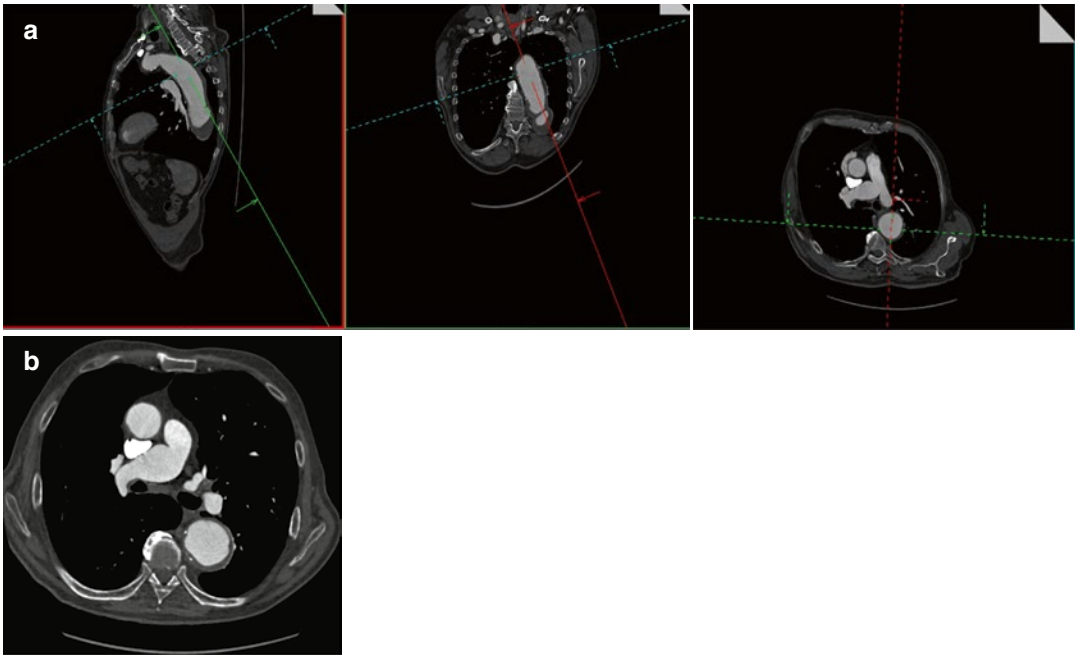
A 77-year-old woman with descending aortic aneurysm. Multiplanar postcontrast CT images show the correct (a) technique of wall-to-wall measurement of the descending aortic aneurysm perpendicular to its center
